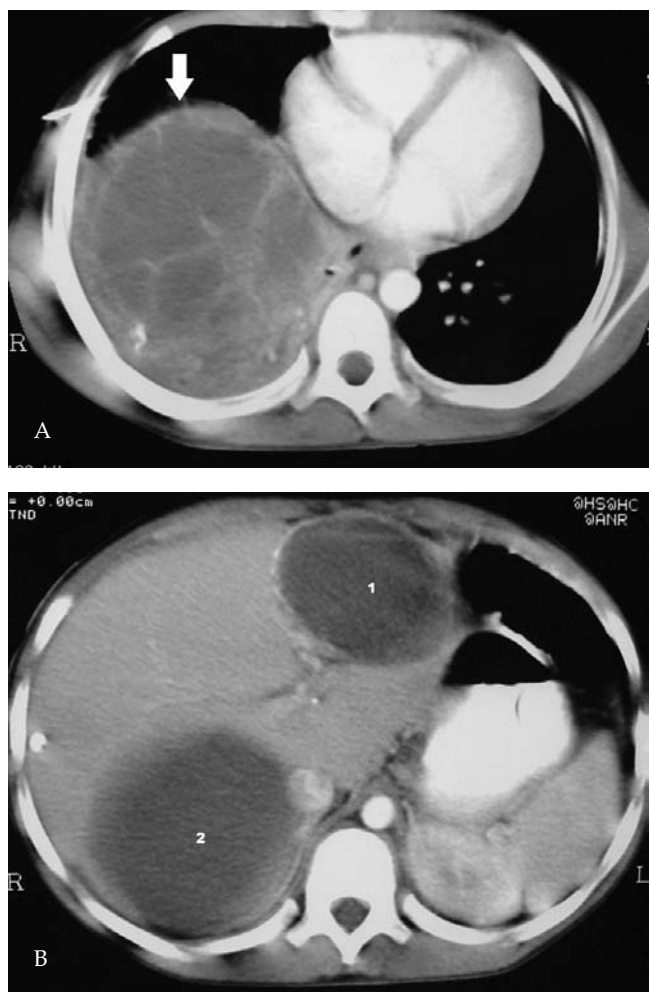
A: Axial, contrast-enhanced CT scan of the liver demonstrating a large septated, cystic mass in segments 7 and 8 (arrow). B: Axial, contrast-enhanced CT scan of the liver, demonstrating homogeneous fluid in abscesses in segment 3 and 4B of the left lobe (1) and segment 5 and 6 of the right lobe (2).
